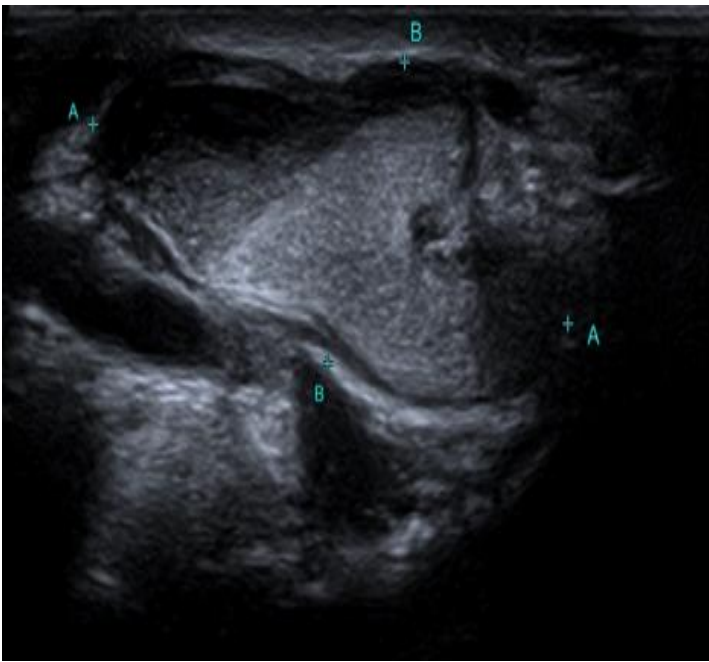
and 8): A 35 years old male patient complaining from radial sided wrist pain figure 7 shows Ultrasound images show ganglion cyst with internal echoes and leveling that was related to ABL and radial artery. Figure 8 shows MRI images show same ultra-sonographic findings.
